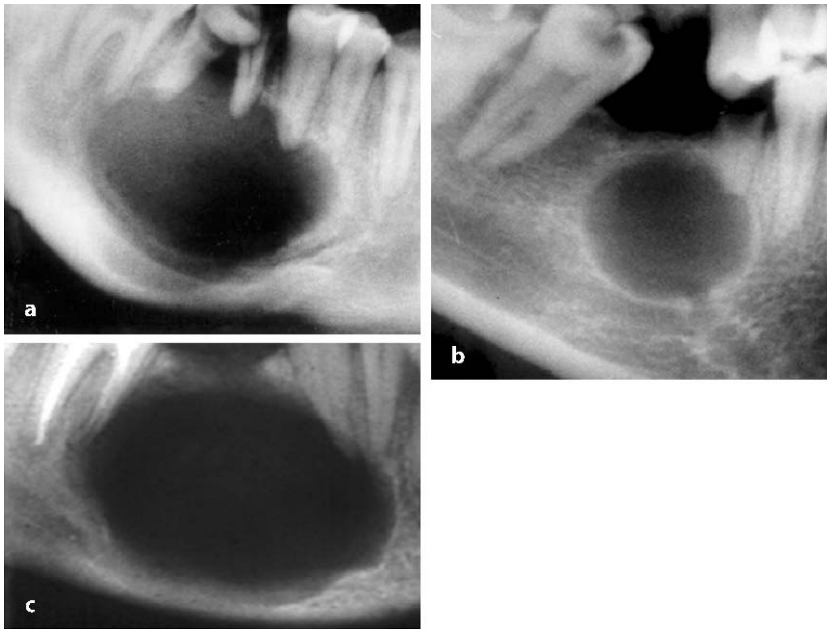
Large apical periodontal cyst on a mandibular first molar (a) and premolar (b); and residual radicular (apical periodontal) cyst (c) following removal of the “causative” tooth. Note the small periapical radiolucency associated with the overfilled distal root of the adjacent molar tooth in (c)
